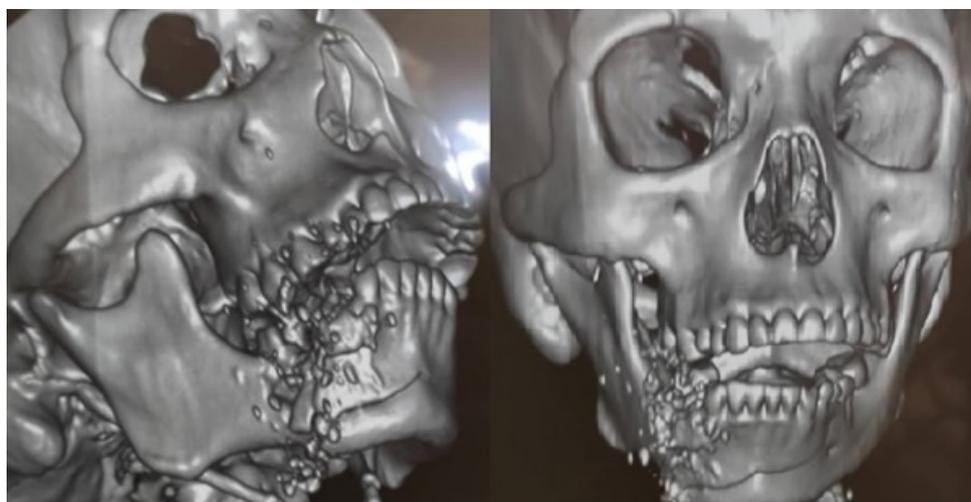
CT scan without contrast with 3D reconstruction of facial bones.
